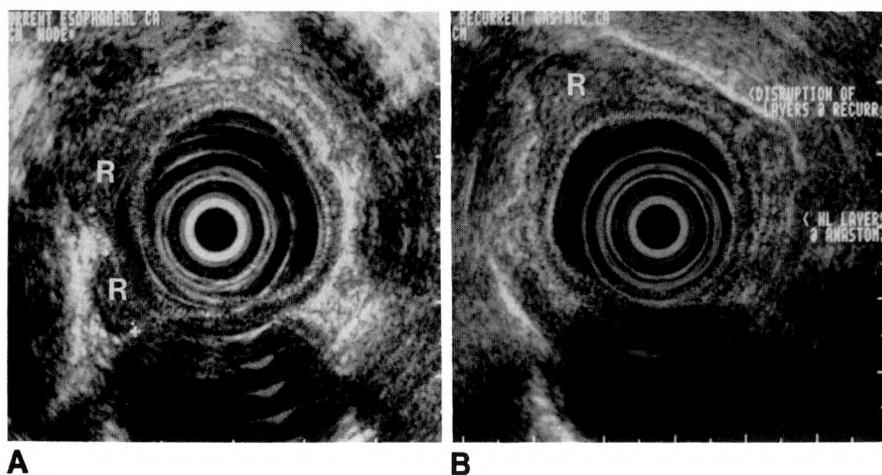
Endoscopic sonography of tumor recurrences with 7.5-MHz transducer.
